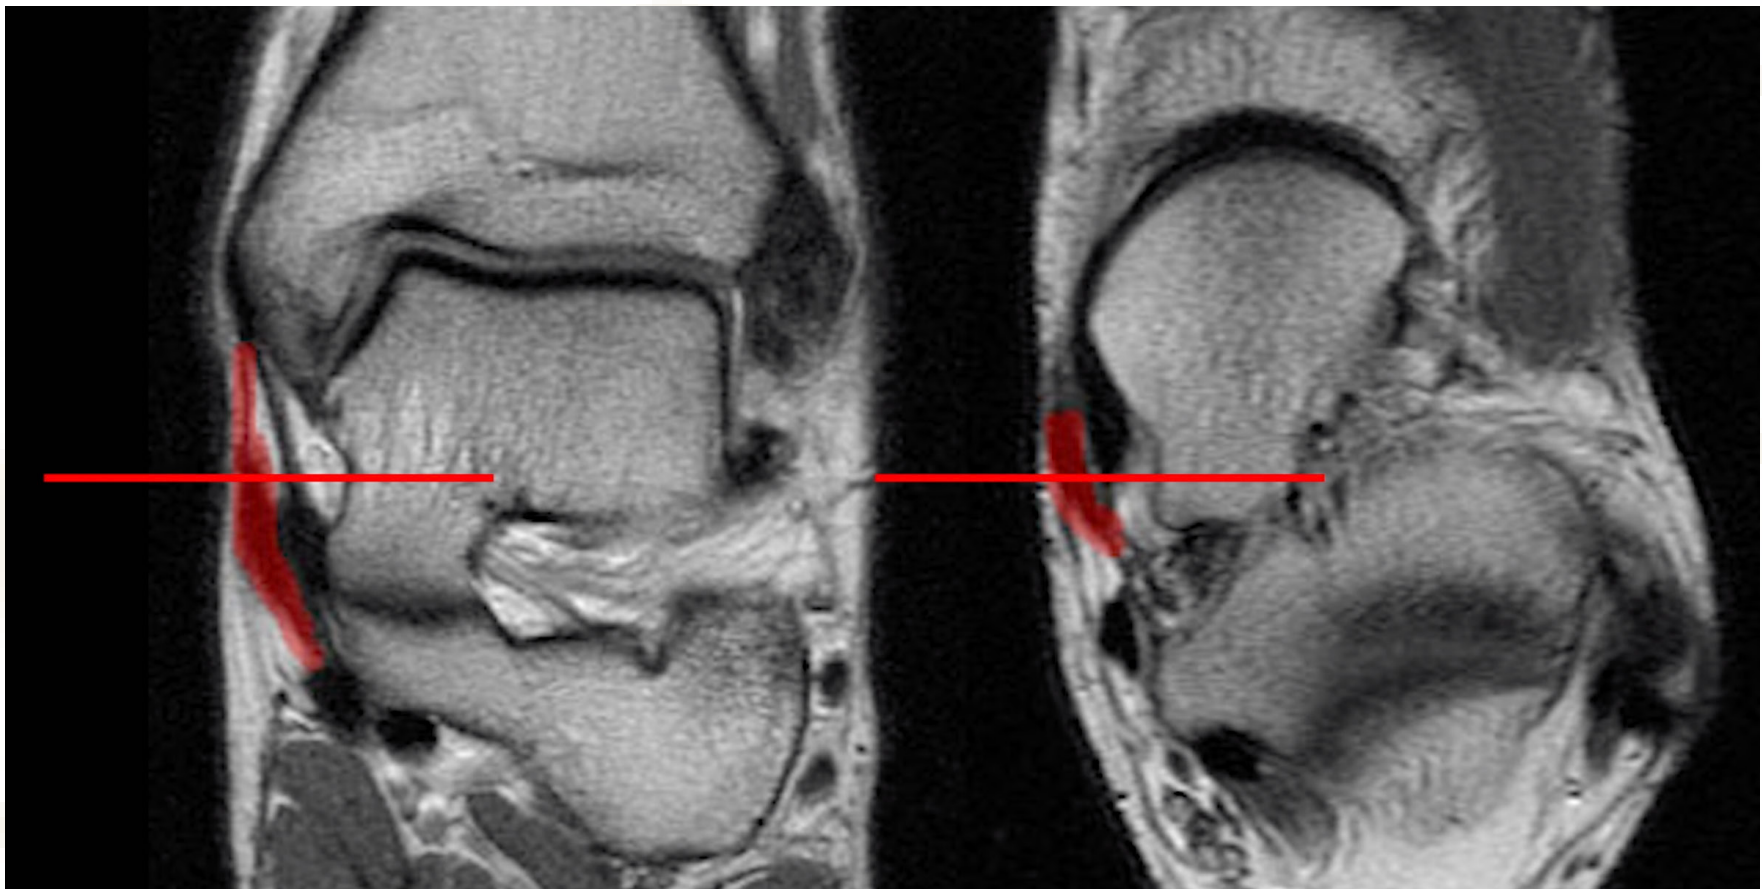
MRI showing the level of deltoid sectioning in red, A: Coronal, B: axial
